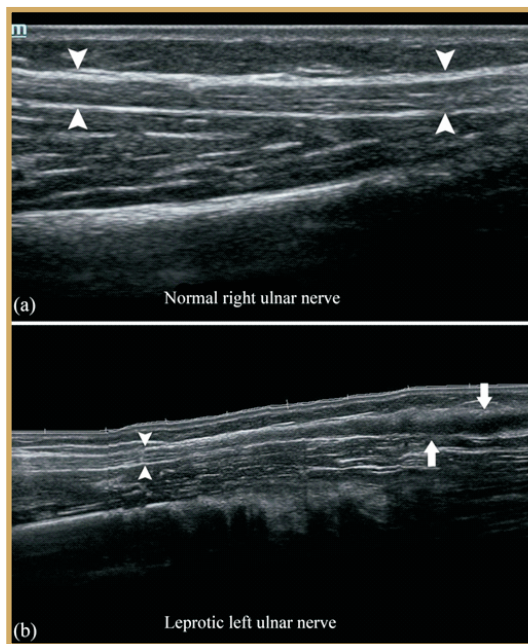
Ultrasonography panoramic view reveals normal right ulnar nerve with hypoechoic nerve fascicles and intervening hyperechoic perineurium giving the bundle of straws appearance (arrowheads in a). The left ulnar nerve shows fusiform enlargement with loss of fascicular architecture and hypoechogenicity distally (arrows in b; the arrowheads point towards normal segment of the nerve).
